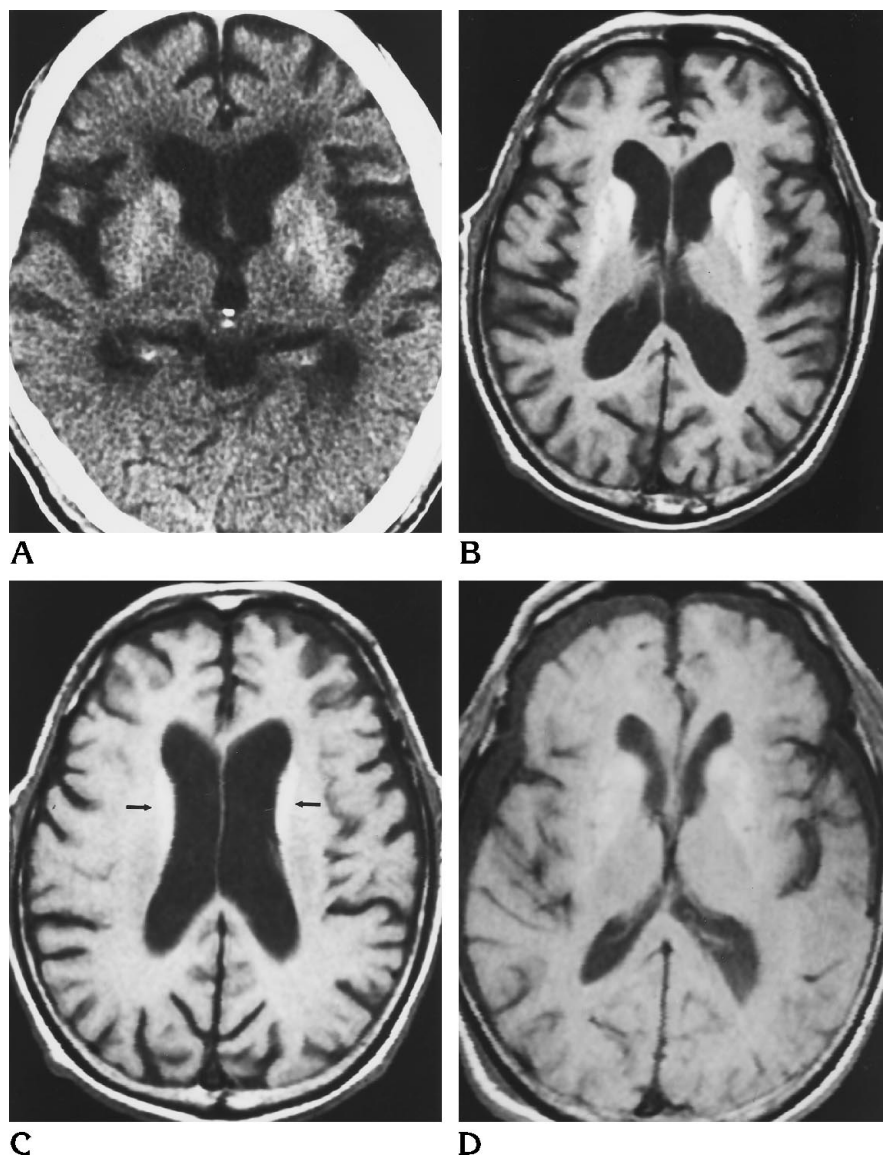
Case 2: 78-year-old man with diabetes in whom bilateral involuntary choreoathetoid movements of the face and limbs developed suddenly. CT scans were obtained 5 days after onset of chorea-ballismus; MR images after 7 days.
